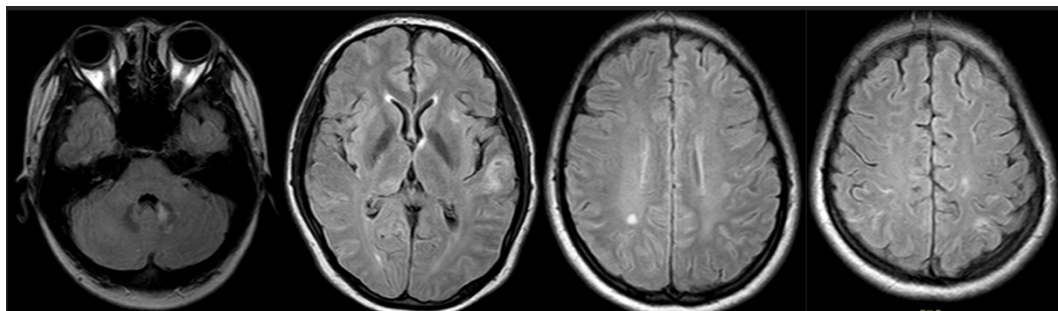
MRI head with contrast (FLAIR sequences) before the combined therapy was initiated. Multiple ICH and perifocal edema on the left side (periventricular IV), on the right side of cerebellum, and thalamus bilateral. Enhancement of the frontoparietotemporooccipital sulci bilaterally, partially seen with hemorrhagic components
